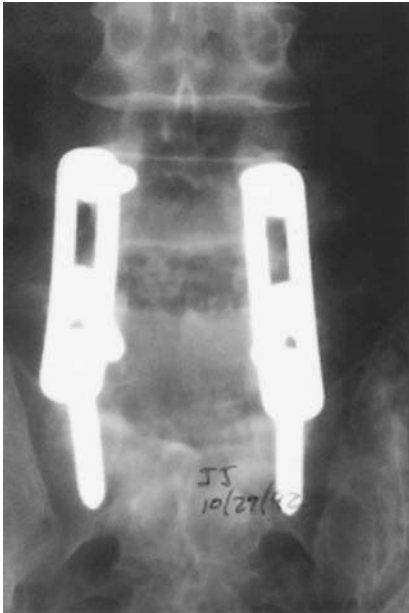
Three-month postoperative AP x-ray. The densities of cage and cancellous bone graft are approximately the same. (From Ref. 33.)
